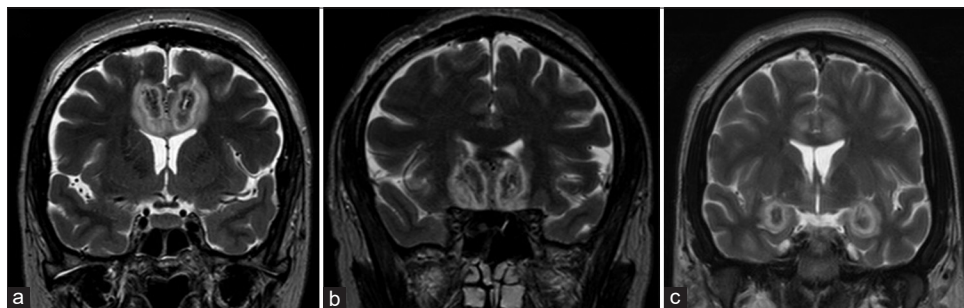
Postoperative T2-weighted MR coronal images of patient 3 showing the bilateral anterior cingulotomy (a), subcaudate tractotomy (b), and amygdalotomy (c) radiofrequency lesions.
